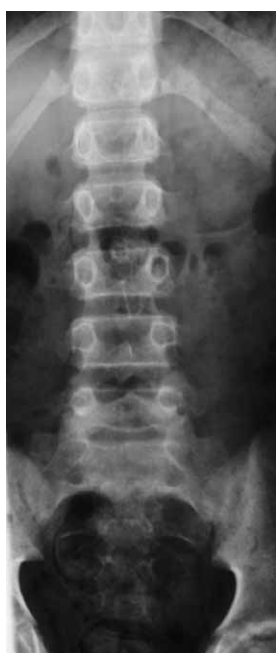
Standard radiographs of L-S spine in AP projection: transitional vertebra S1 (lumbalisation) type IIIA according to Castellvi et al. Patient S.T., 16 years (boy).
